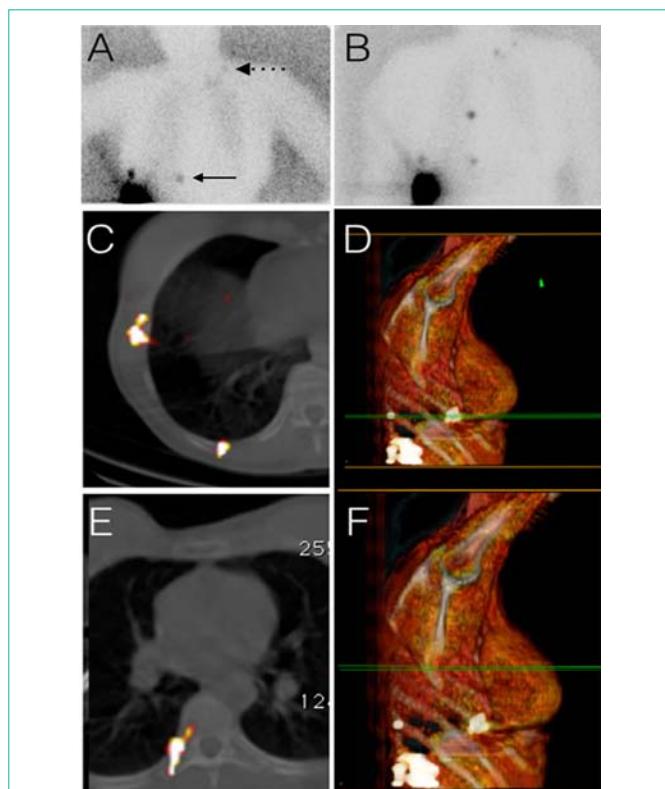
Lymphoscintigraphic planar image corresponding to the anterior thoracic area. The image depicts a high-intensity hot spot located upper to the injection site and another, less intense, hot spot medially (arrow). In left supraclavicular area there is another faint hot spot (dotted arrow) (A). The anterior view performed at 120 min after injection showed some more hot-spots, especially in medial area (mediastinum) (B). Axial slice of SPECT/CT fused image showing two hot spots in right paracostal area (C). Volume rendering reconstruction showing the location of these nodes (D). Axial slice of SPECT/CT fused images in an upper level showing uptake near costovertebral area (E). Volume rendering image that shows the level of the previous commented slice.(F).
